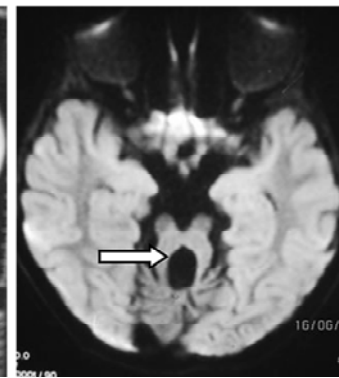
Axial MR FLAIR showing characteristic molar tooth sign suggestive of Joubert syndrome
